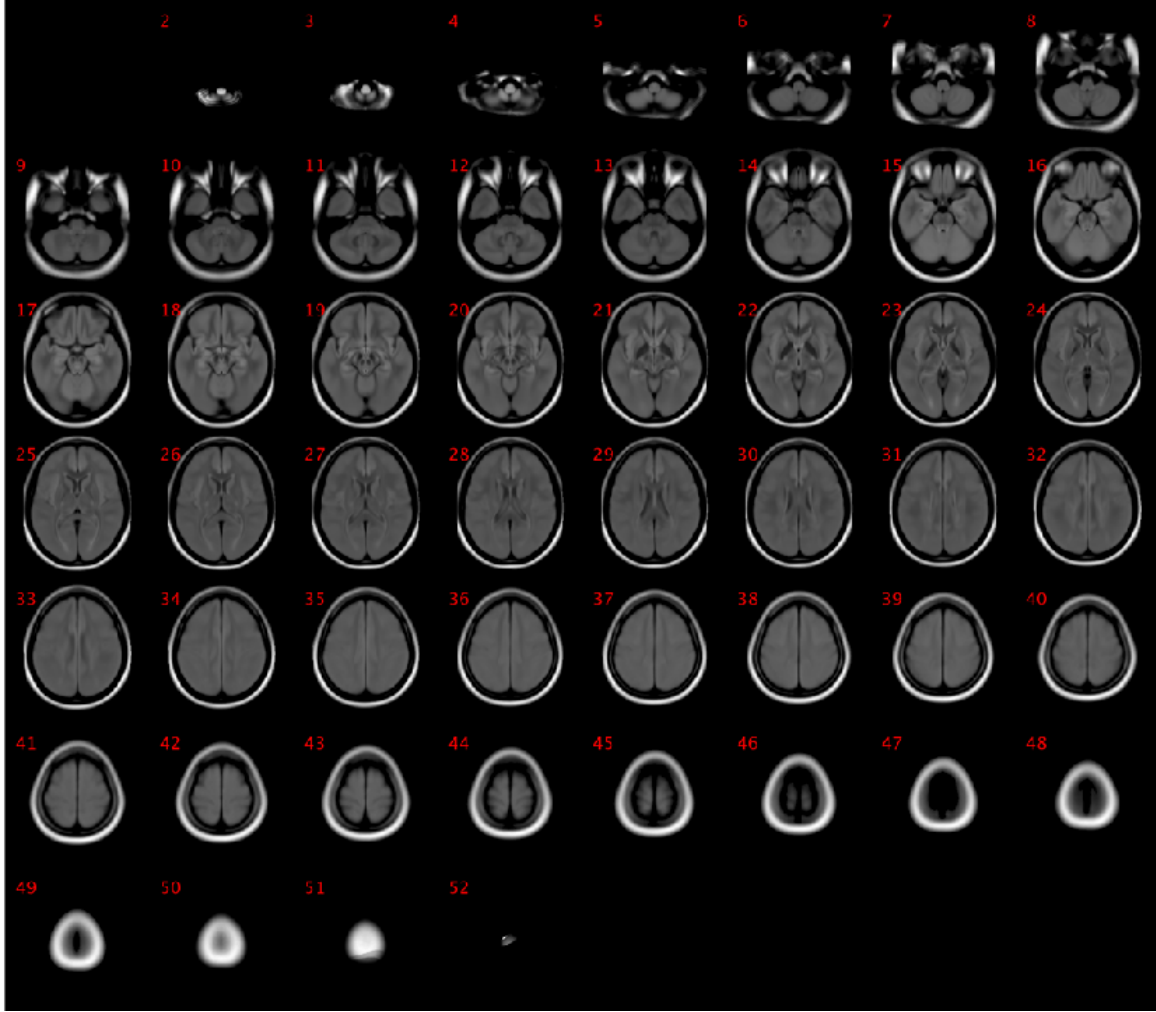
The FLAIR atlas provided by [68] Brainder.
